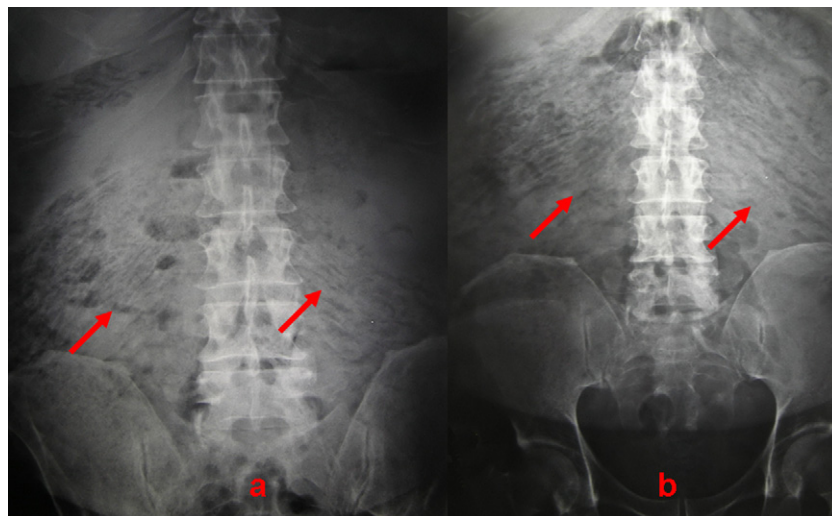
X-ray images showing the presence of subcutaneous gas.
